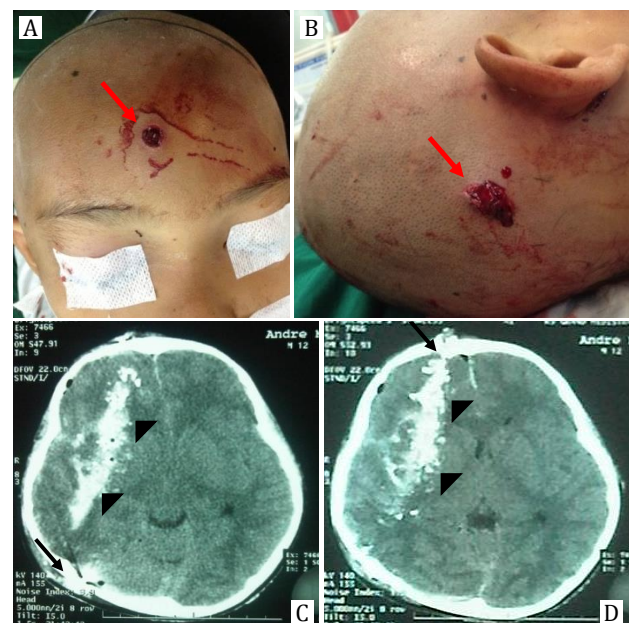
A,B) Missile enters from mid frontal and comes out from right occipital (red arrow); C,D) Head CT scan shows fracture on the frontal and right occipital, intracerebral hematoma (black arrow) along the missile track from frontal through right occipital (arrowhead). Sulcus and gyrus are hard to visualize. Extensive perifocal edema and midline shift are more than 5 mm
